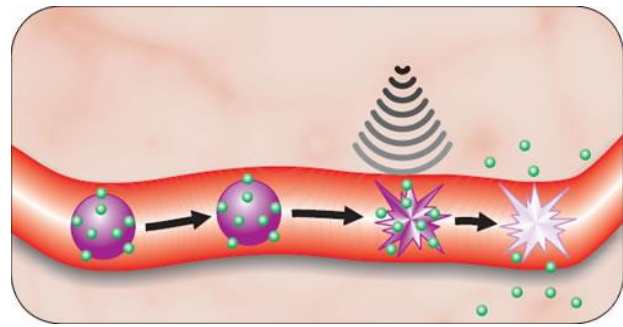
shows the working of Micro bubbles and the effect of ultrasound on it.
